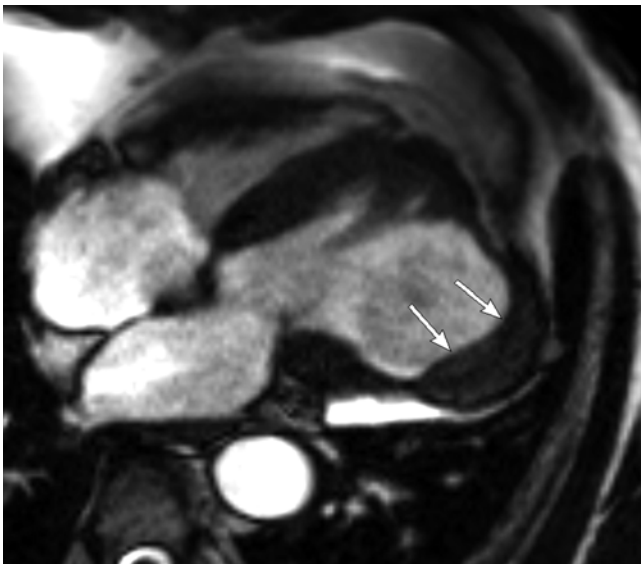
MRI of a patient with pseudoaneurysm of LV in lateral wall. Cine MRI with 4-chamber view shows a large wide-neck aneurysm in lateral wall with thrombus (*arrows*)
